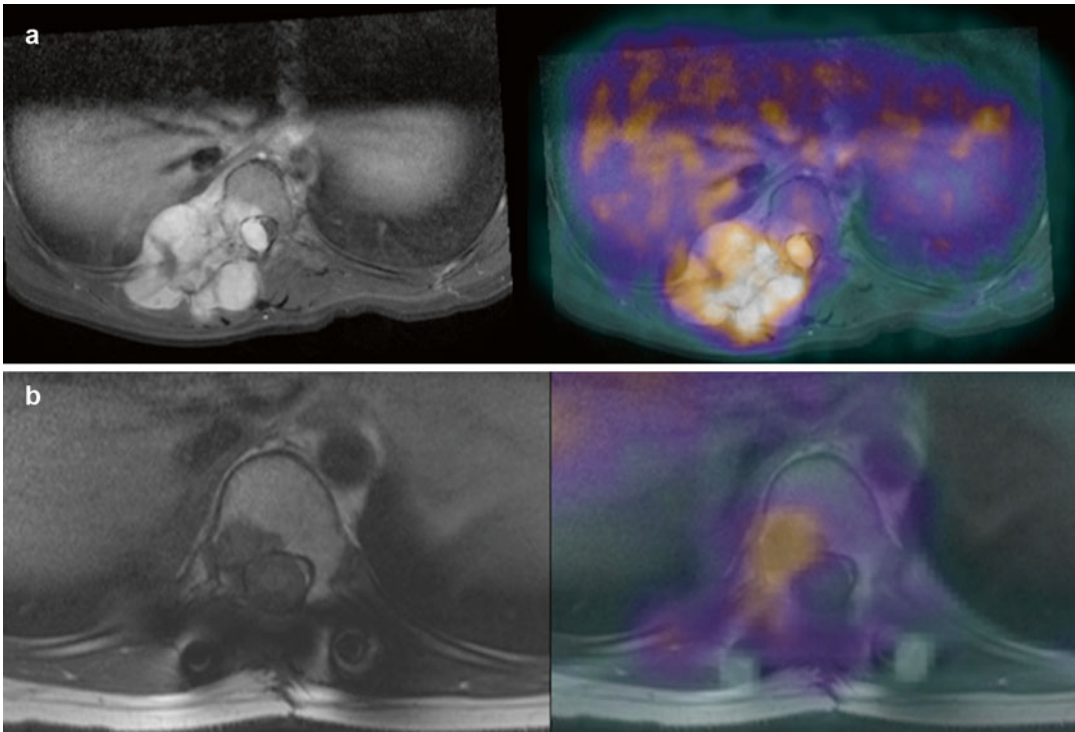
Malignant peripheral nerve sheath tumor. A 12-year-old female presented with a painful right paraspinous mass. MRI showed tumor extension into the spinal canal and involvement of the head of the 10th right rib. Fluorine-18-FDG PET/CT was performed and co-registered with MRI (a: top row MRI (left) and co-registered image (right)). The mass has moderately increased metabolism (SUVmax 4.2) with no metastatic disease. Biopsy
